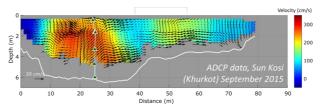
Example of Acoustic Doppler Current Profiler Data, showing sample locations (triangles), channel architecture and water velocity distribution.
